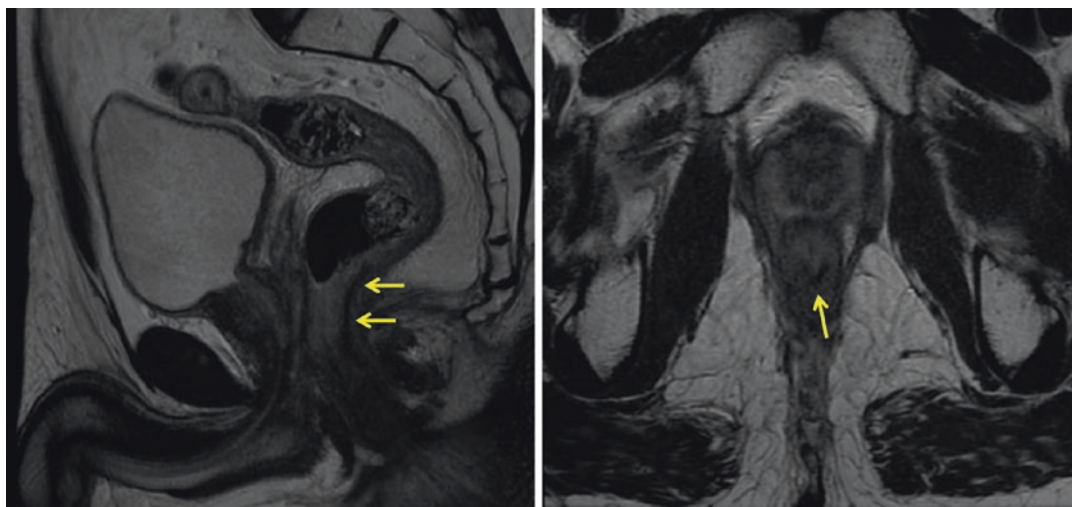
MR imaging of rectal cancer after neoadjuvant treatment showing complete radiological response, as low signal intensity
